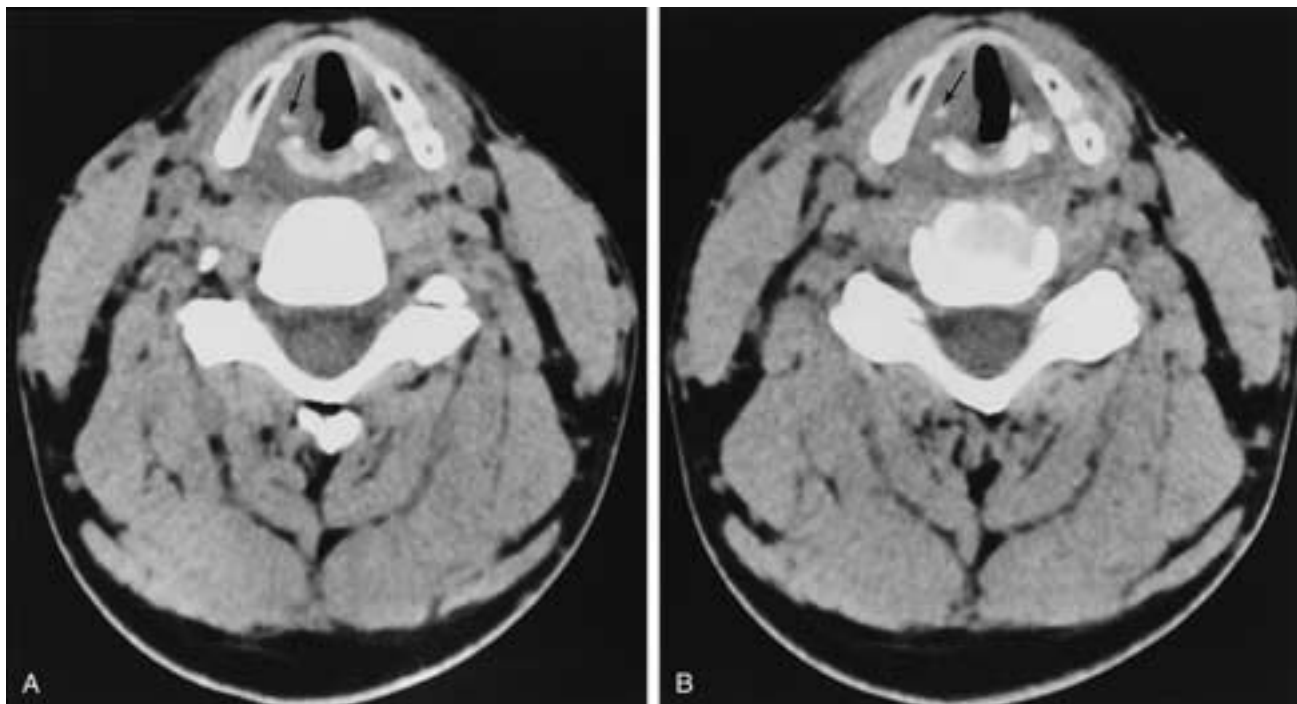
Axial CT. A, The arytenoid is anteriorly displaced (*arrow*). B, Slightly lower scan again shows the abnormal position of the arytenoid (*arrow*).
